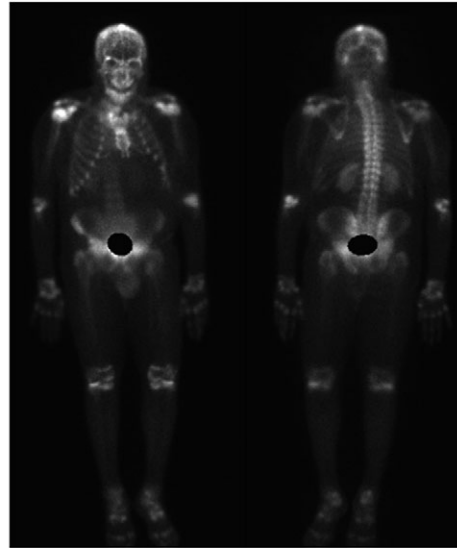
bone scintigraphy with technetium (focus).
